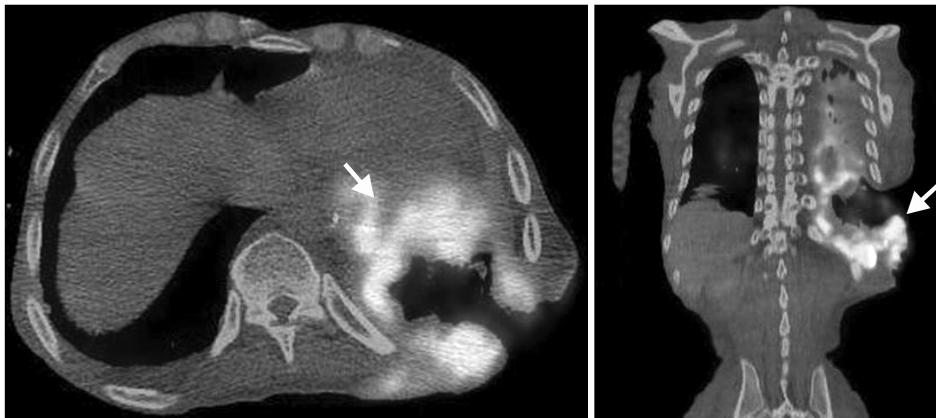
Whole body PET-CT reveals the hypermetabolic lesions in left lower chest wall around Eloessor open window with widely direct invasion to pleural cavity and left lower lung.
